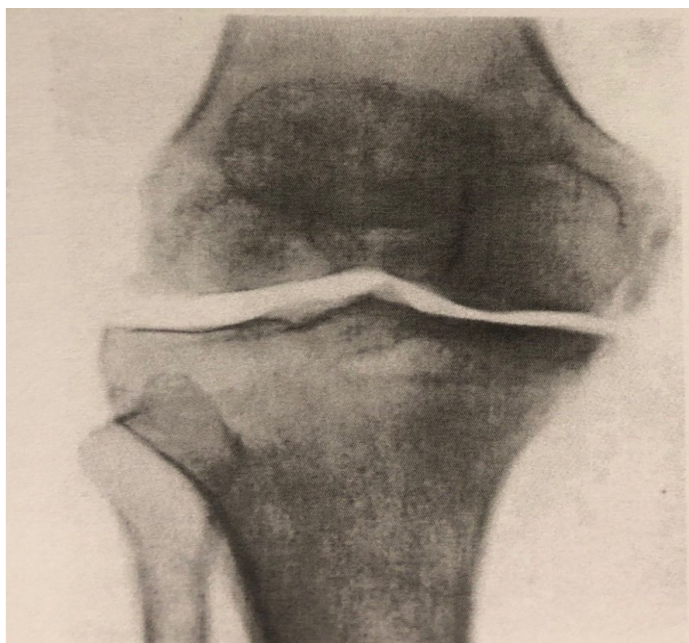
X-ray of a patient in lying position [6]
